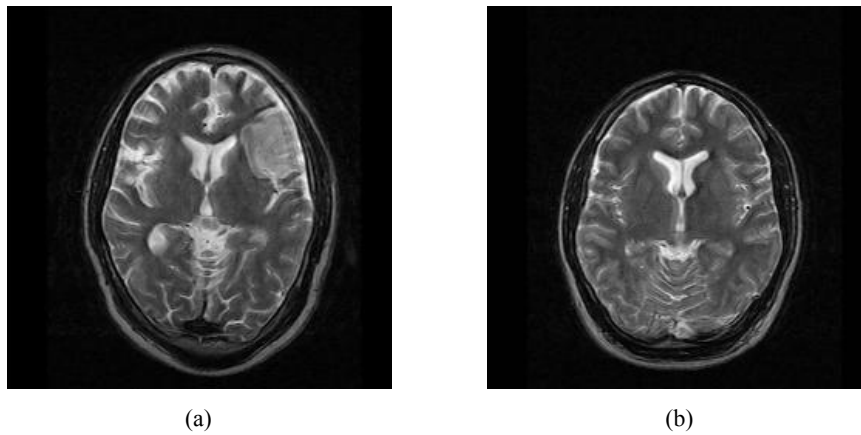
Sagittal views of brain MRI images, (a) tumour (b) non-tumourFigure 3 Axial views of brain MRI images, (a) tumour (b) non-tumour
